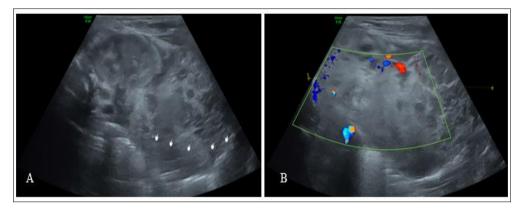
There is a large tissue mass, seemingly arising from the right liver, that is poorly circumscribed with irregular borders and a heterogeneous echotexture containing hypoechoic areas (Fingers) (A). The lesion is vascularized on color Doppler imaging (B) and measures approximately 11.5 cm at its greatest diameter.
